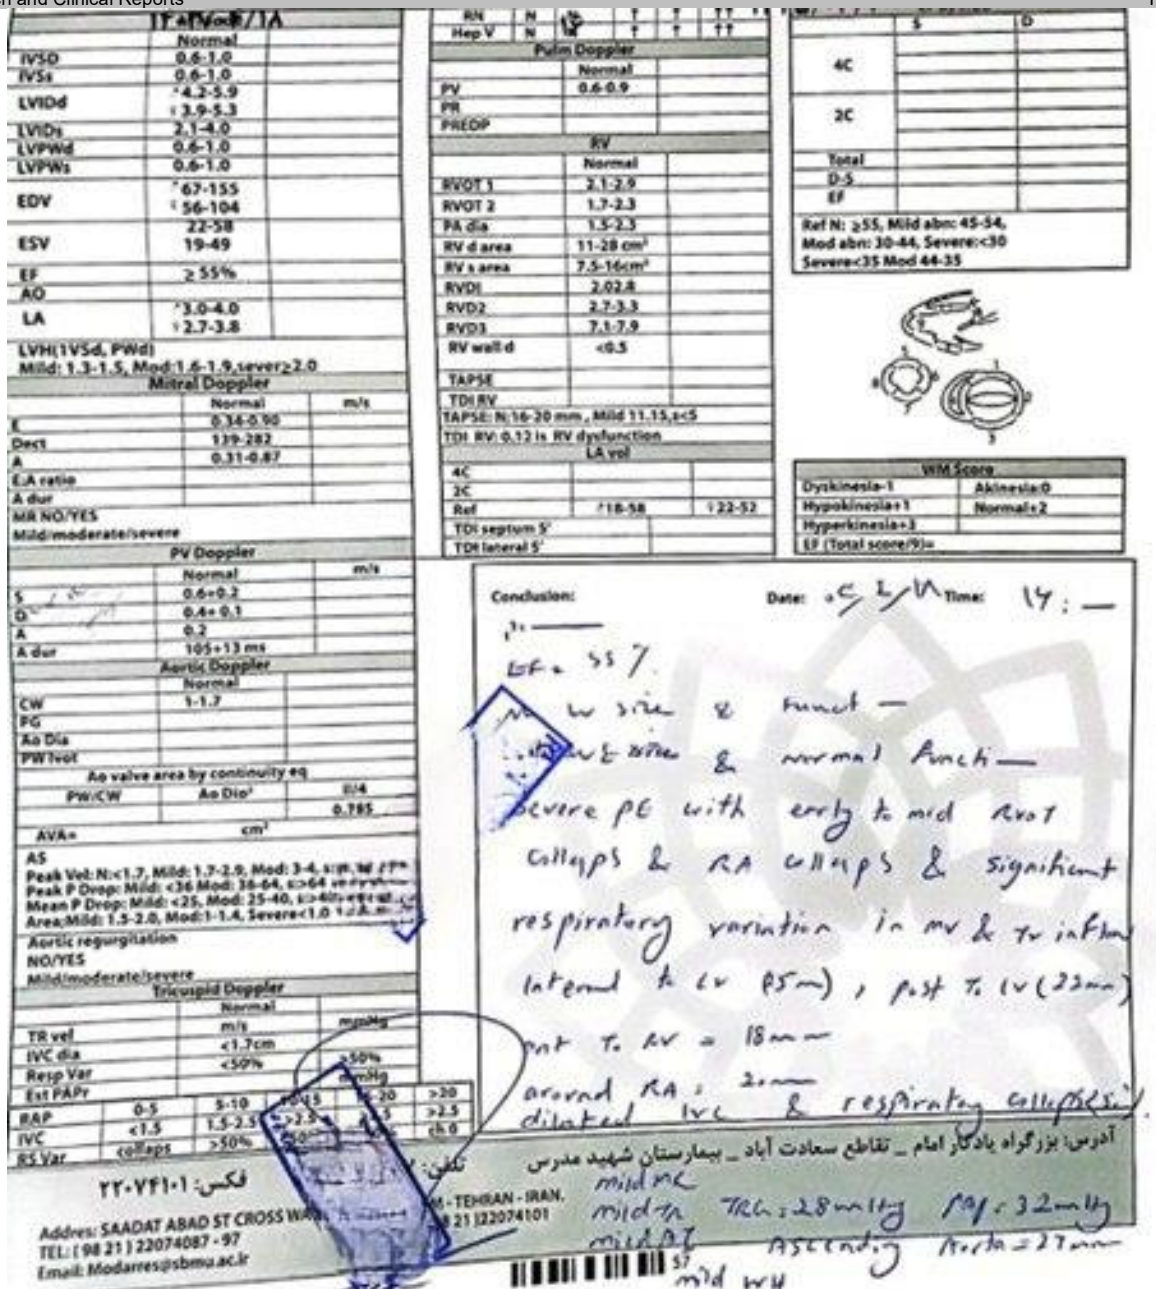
echocardiography report, it revealed severe pericardial effusion (ranging from 15 to 22 mm), with early right ventricular collapse and significant respiratory variation.
